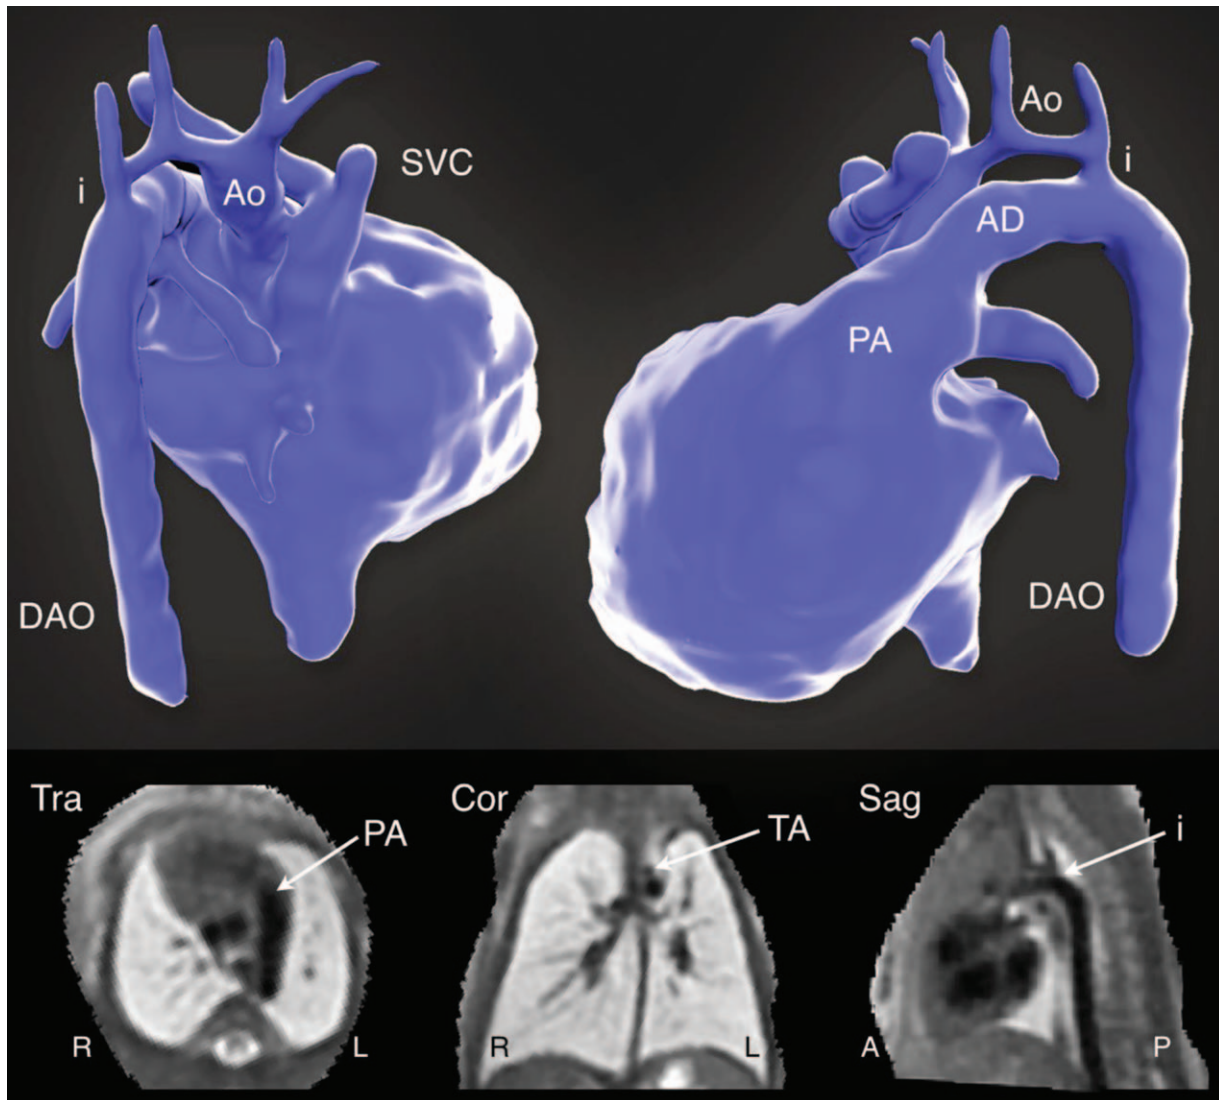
Volumetric reconstruction of T2-weighted multiplanar single shot fast spin echo (ss-FSE) MRI in a 33-week gestational age fetus with coarctation of the aorta. A volume rendering of the blood pool is shown in posterior projection (top left) and left lateral projection (top right). The bottom panel shows planes from the volumetric reconstructed data in transverse (Tra), coronal (Cor), and sagittal (Sag) orientations. The aorta (Ao), arterial duct (AD), descending aorta (DAo), aortic isthmus (i), pulmonary artery (PA), transverse arch (TA), and superior vena cava (SVC) are labeled. Reprinted with permission from Lancet 2019; 393:1619–1627 used under CC BY.
